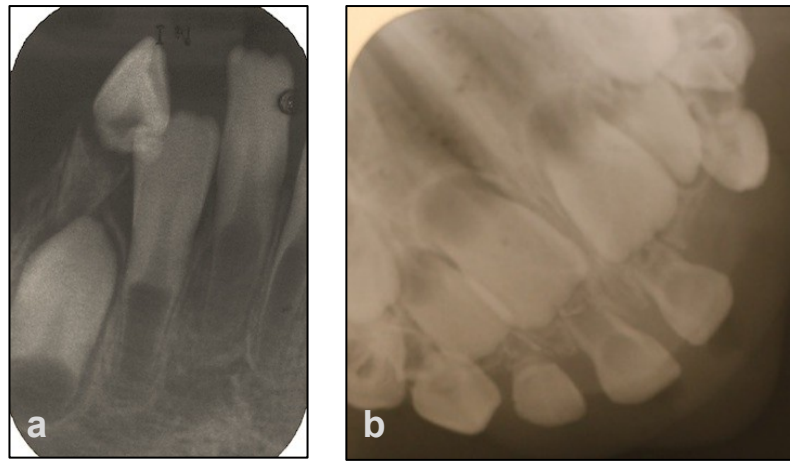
a) Right and b) left vertical bitewings of an OI patient (ID=23). Pulp and crown size appears normal.
